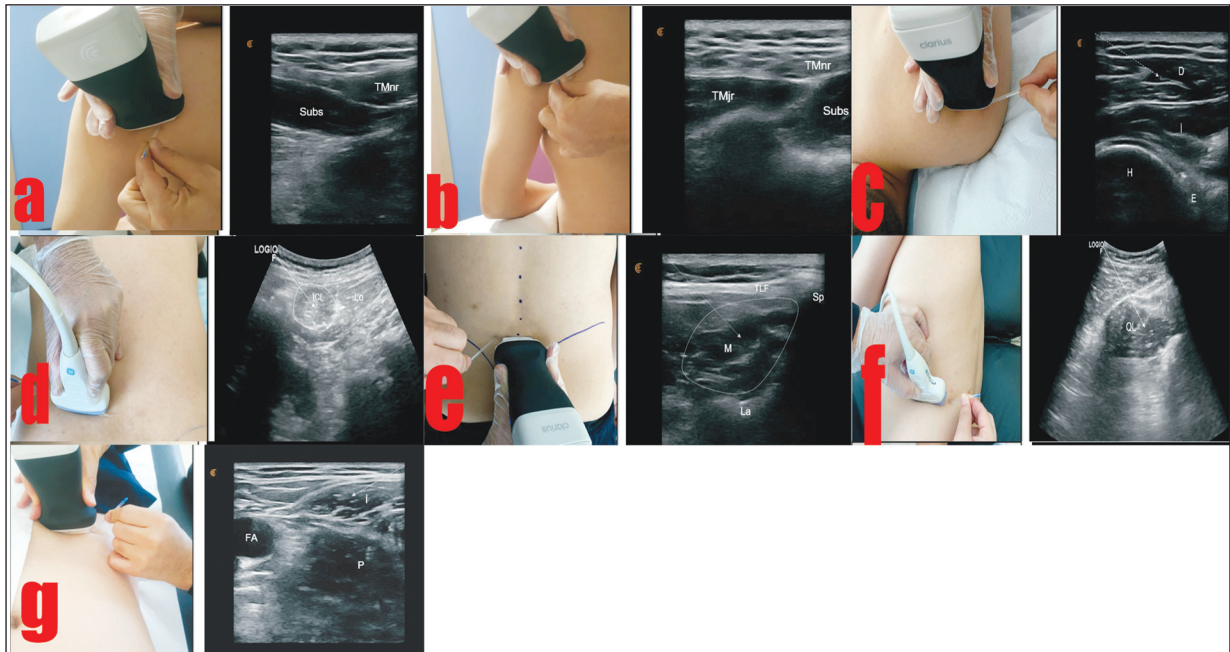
a: Sonographic image of the subscapularis(Subs) muscle and the teres minor (TMnr) muscle; b: Sonographic image of the teres major (TMjr) muscle; c: sonographic image of the infraspinatus(i) muscle and the deltoid(D) muscle; d: sonographic image of iliocostalis(ICL) and longissimus(Lo) muscle; e: sonographic image of the multifidus (M) muscle; f: sonographic image of the quadratus lumborum (QL) muscle; g: Sonographic image of the psoas (P) muscle and iliacus (I) muscle.
